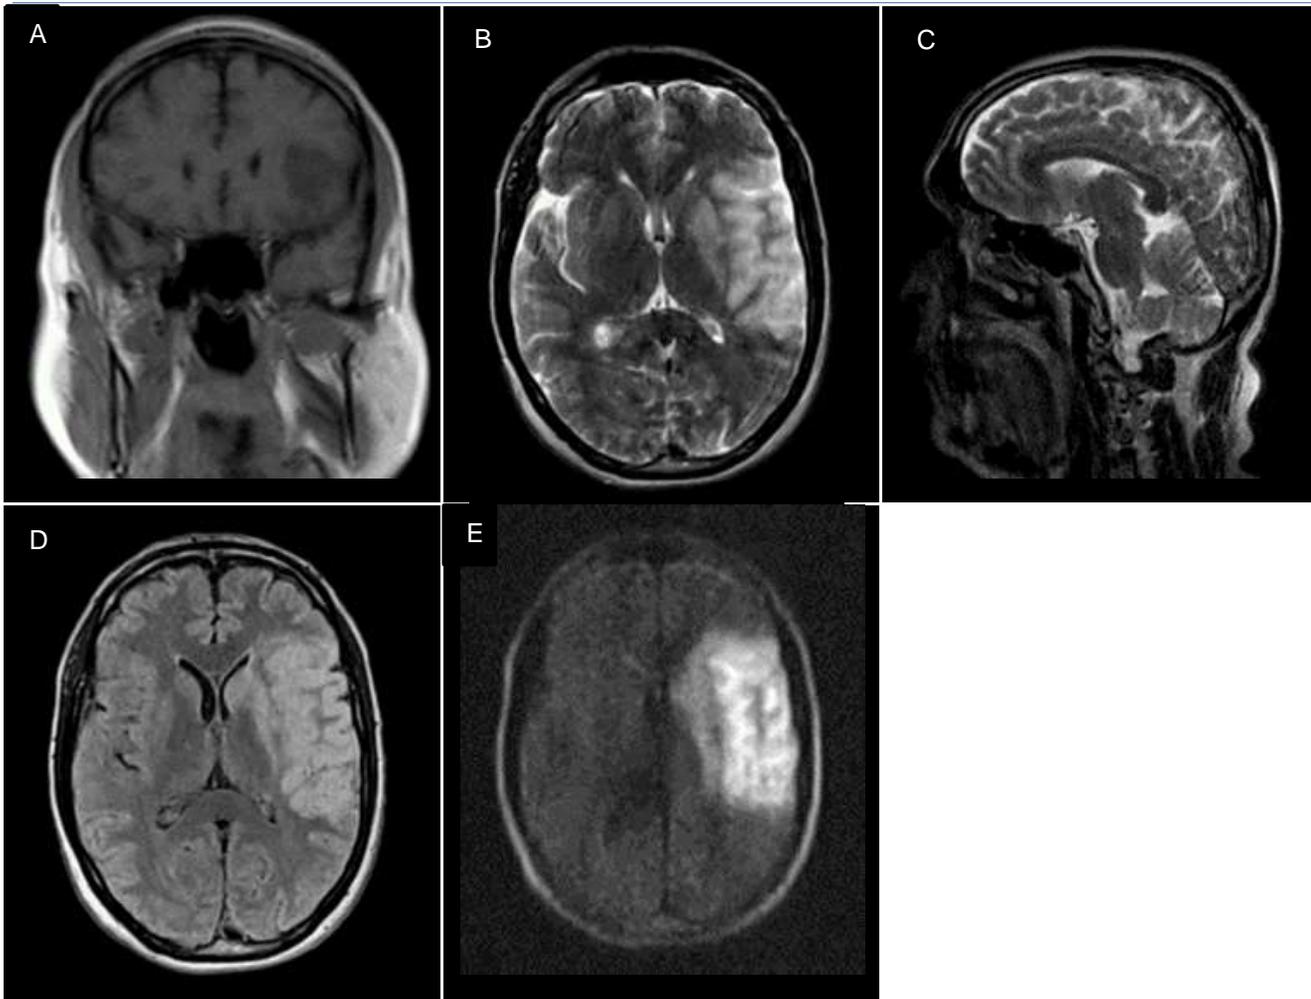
(A) this coronal image of MRI shows a hypointense (dark) lesion in the temporal lobe of the brain, on T1 sequence of MRI. (B) this axial image shows a hyperintense lesion on T2 sequence of MRI (in the temporal lobe) (C) this sagittal image shows a hyperintense (bright) lesion on T2 sequence of MRI (temporal lobe) (D) this axial image of MRI shows a hyperintense (bright) lesion in the temporal lobe on FLAIR sequence of MRI. (E) this axial image of MRI shows a hyperintense lesion in the temporal lobe of brain on DWI sequence of MRI.
